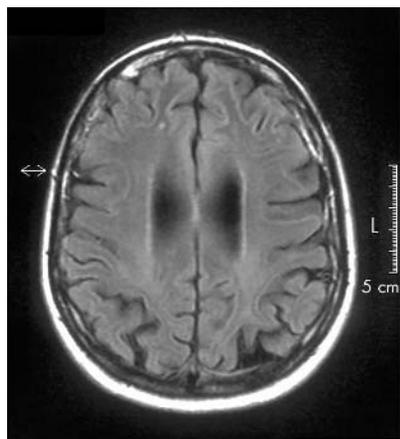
FLAIR MRI demonstrating mainly posterior cortical atrophy.
